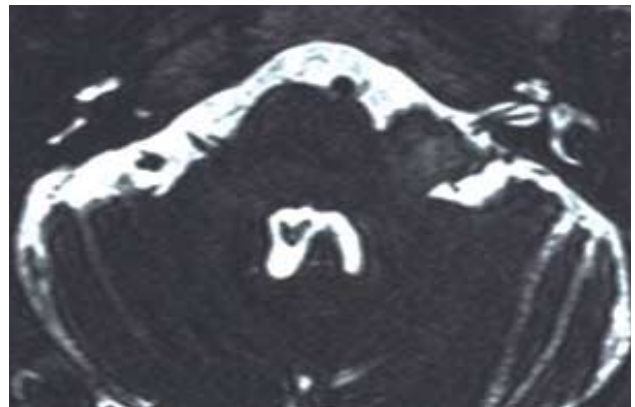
MRI: Axial T2 sequence. The lesion developed next to the inner auditory canal without extending into it. The cochlear and vestibular nerves can be seen. MRI = magnetic resonance imaging.
